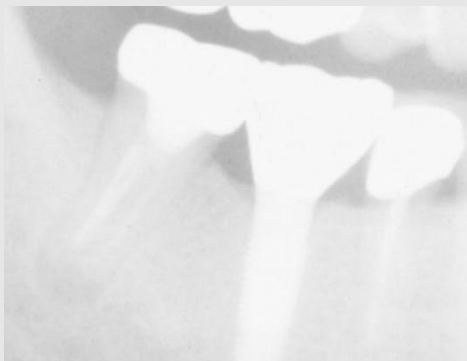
Failure case: pre-op periapical view.
